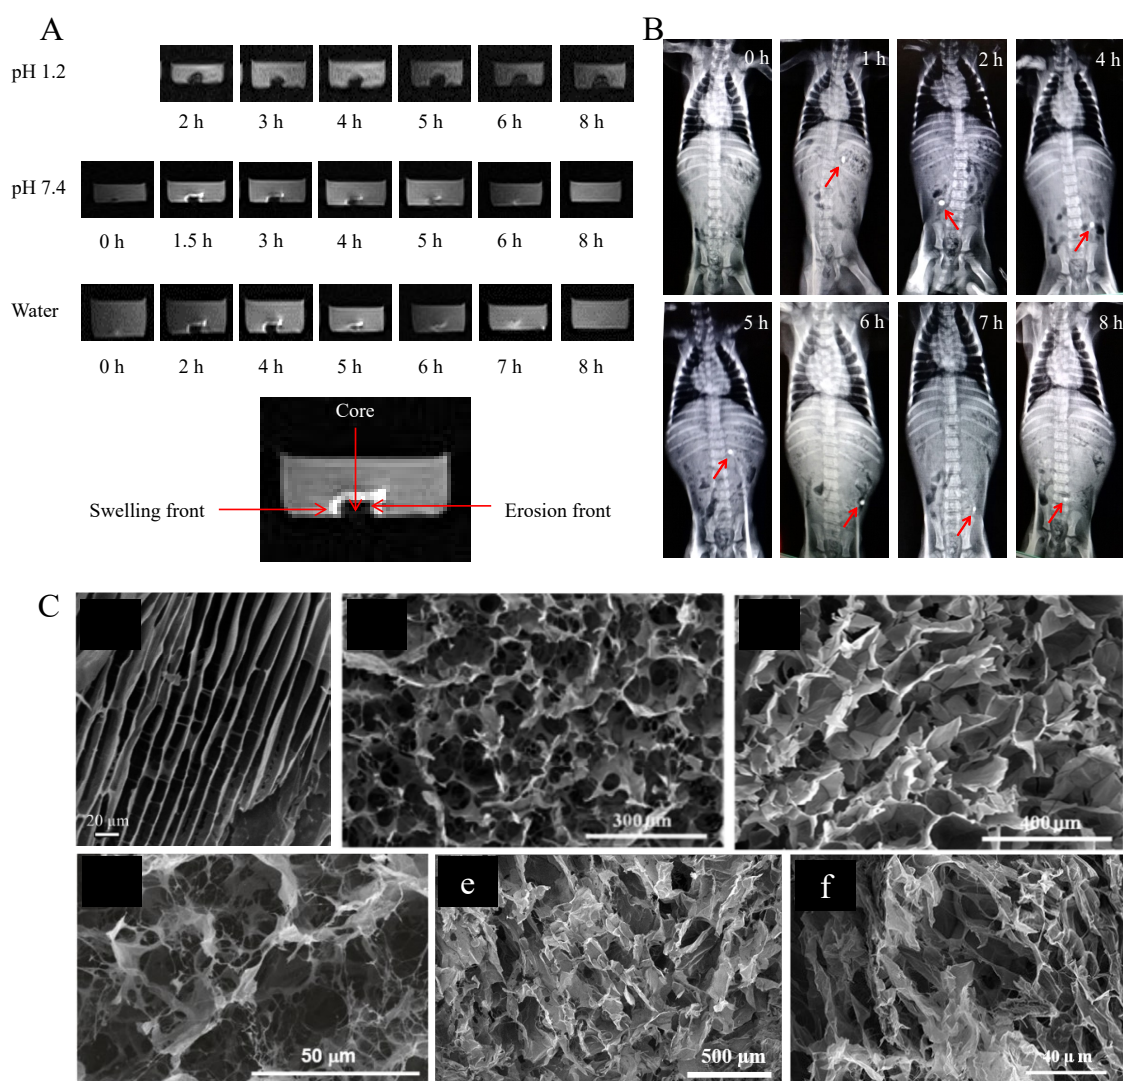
MRI images (A) of swelling behavior of AVH tablets (AVHM) in water, at pH 1.2 and 7.4 after different time intervals<sup>28</sup> (reproduced with permission from the Royal Society of Chemistry); *In-vivo* X-ray studies (B) of *Ocimum basilicum* hydrogel (OBH) containing tablets without drugs (FOBH) to track the position of prepared tablets in different segments of the gastrointestinal tract after various time intervals<sup>48</sup> (reprinted with permission from Elsevier); SEM images (C) of the cross-section of water-swollen then freeze-dried samples of LSH (a)<sup>24</sup> (reprinted with permission from Elsevier), and MPH (b)<sup>25</sup> (reproduced with permission from the Royal Society of Chemistry), QH (c)<sup>26</sup> (reprinted with permission from Elsevier), OBH (d)<sup>27</sup> (reproduced under Creative Commons Attribution License), AVH (e)<sup>28</sup> (reproduced with permission from the Royal Society of Chemistry) and PSH (f)<sup>29</sup> (reproduced with permission from the Royal Society of Chemistry)
